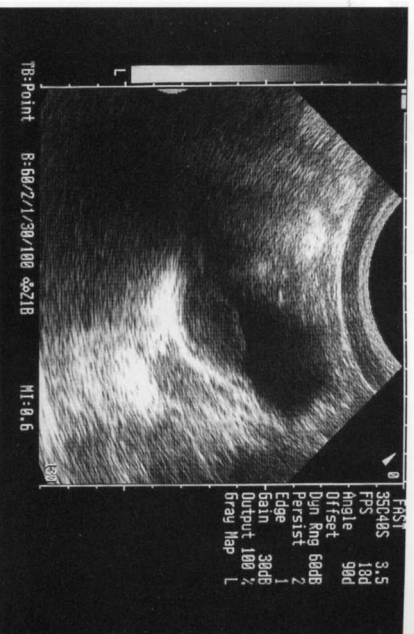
Irregular shaped bladder with layered echoes noted within the bladder in a patient with a pelvic fracture and gross hematuria. The CT scan revealed no hemoperitoneum.
